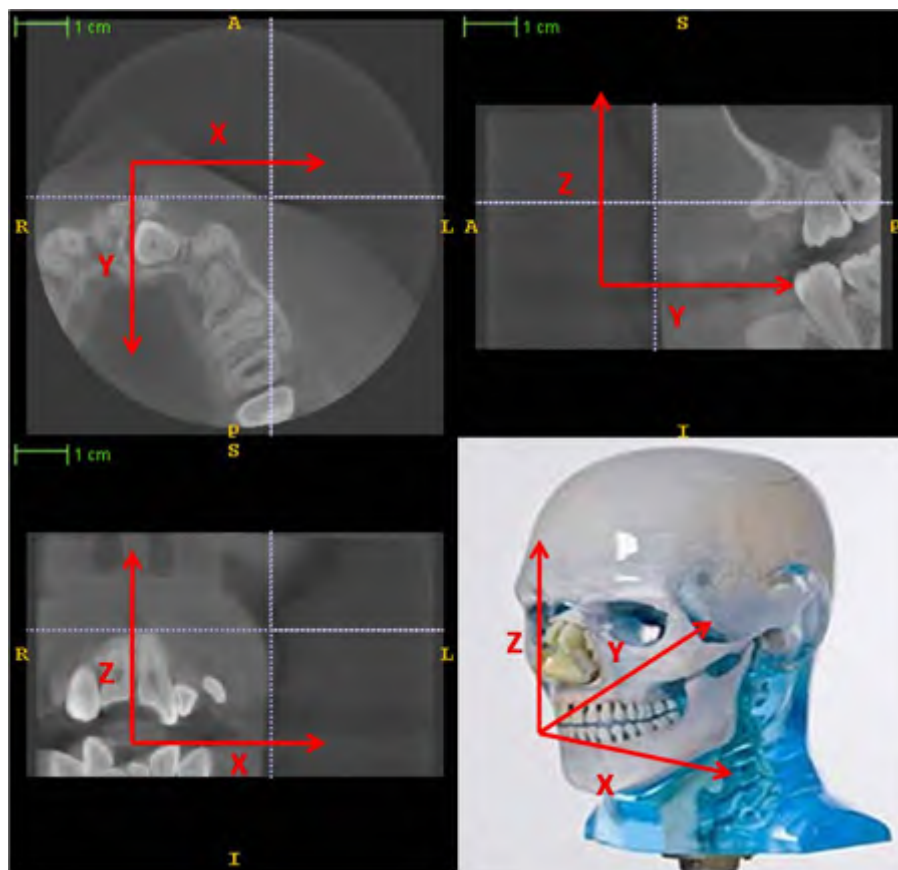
The orientation of the CBCT image: the X axis of the system points from right of the head to the left, the Y axis from anterior to posterior, the Z axis from inferior to superior (The six orientations of the head are labeled by six capital letters: A (Anterior), P (Posterior), L (Left), R (Right), S (Superior), I (Inferior).)
